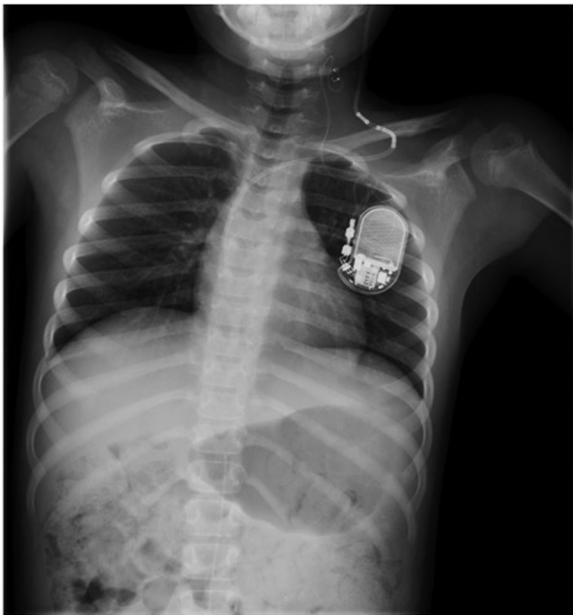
Chest x-ray from 4 years prior to presentation. Shunt tubing noted to be going into the right atrium.
